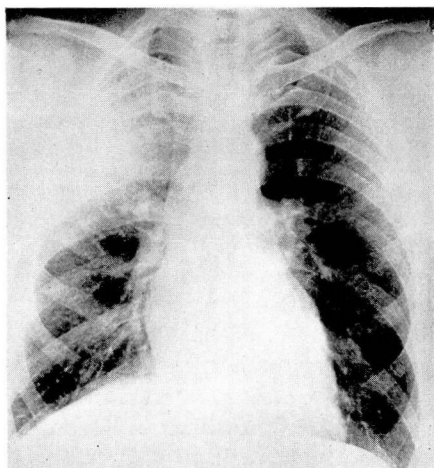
Case 1. Roentgenogram of chest.
